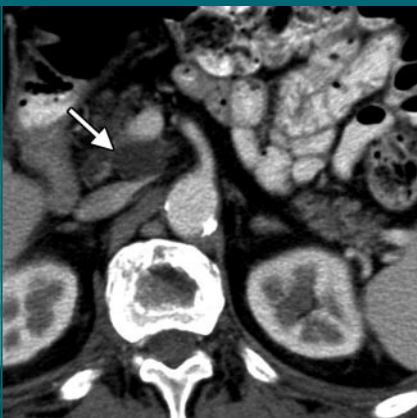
Transverse contrast material-enhanced CT scan of abdomen in 65-year-old woman. A unilocular cyst (arrow) in the uncinate process of the pancreas was detected incidentally and confirmed to be benign intraductal papillary mucinous neoplasm after surgery.
